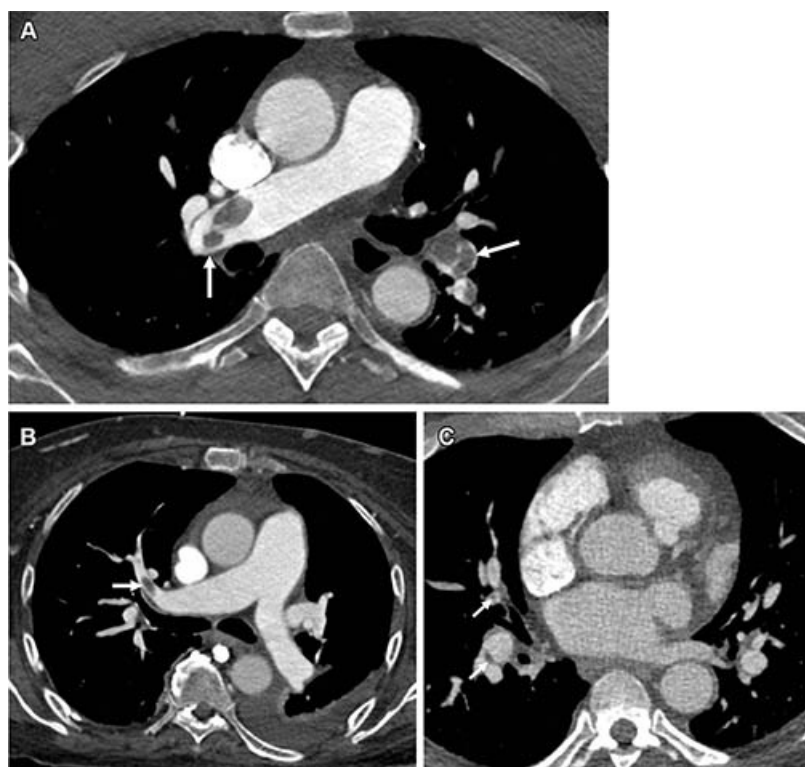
Stages of thromboembolism. (A) Pulmonary embolism (PE) chest axial CT angiography image demonstrating acute pulmonary embolus (arrows). (B) PE chest axial CT angiography image demonstrating subacute pulmonary embolus (arrow). (C) PE chest axial CT angiography image demonstrating webs/scarring from prior pulmonary embolus (arrows).
